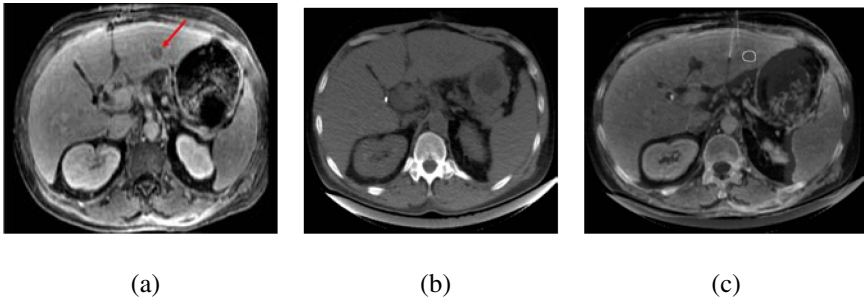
Current RFA procedure. Patient with hepatocellular carcinoma of the left hepatic lobe. The patient was a poor surgical candidate due to other co-morbidities and underwent RFA under CT guidance. (a) The tumor margin can be clearly seen on the pre-procedural MRI. (b) The intra-procedural CT does not have information about the tumor margins. The RFA electrode was placed by estimating the location of the tumor by using other anatomical landmarks. (c) Aligned pre-procedural MR and intra-procedural CT shows that RFA applicator is not placed accurately. The tumor margin was drawn based on the information provided by pre-procedural MRI.
